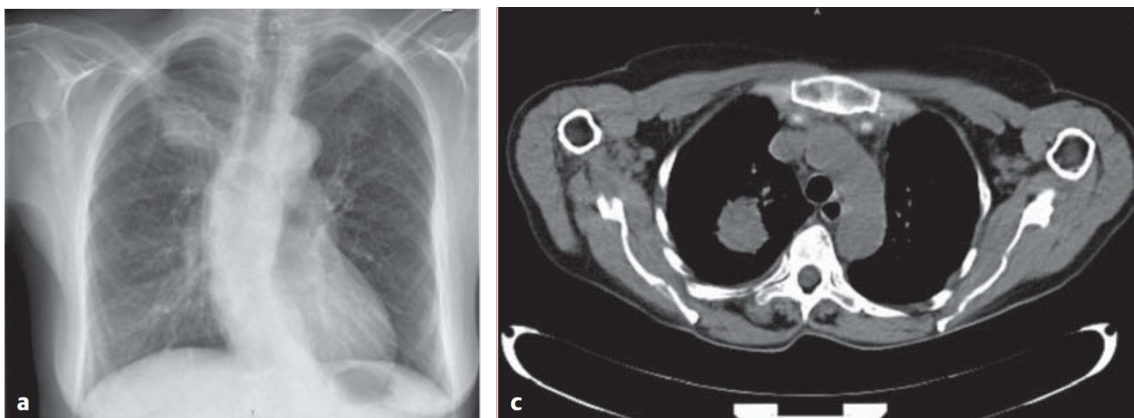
Lung tumor in X-Ray and CT scans
